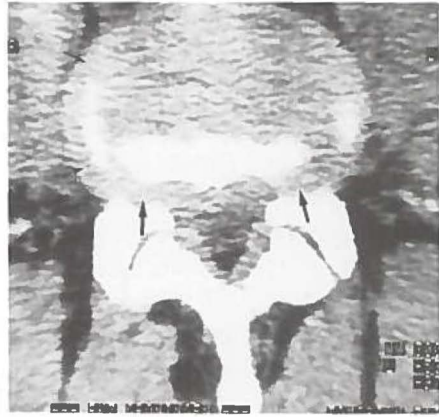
Case 5. CT scan at the same disc level. Three months after chemonucleolysis there is no focal abnormality, but the diffuse annular bulging has increased (small arrows) with obliteration of foraminal fat at this level (arrows).
